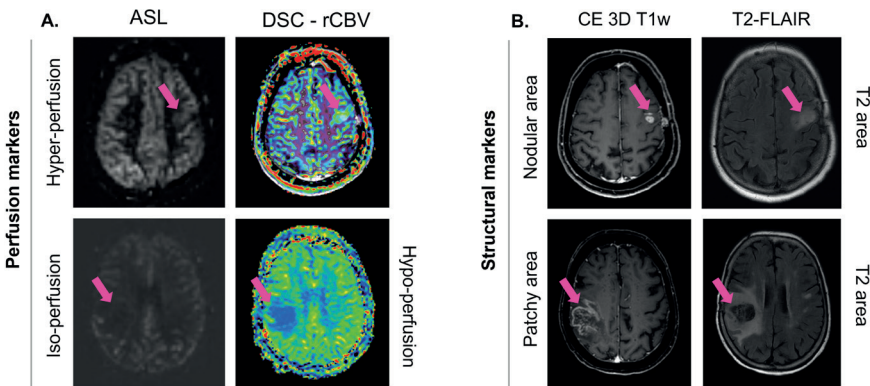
Examples of some of the MRI markers scored by a neuroradiologist. A. Perfusion MRI markers retrieved from corresponding images, namely ASL and DSC-rCBV maps. On the upper and lower row examples of patients with increased and no change/decreased perfusion, for ASL and DSC respectively. In B. contrast enhanced (CE) 3DT₁ and T₂-FLAIR MRI scans from which the structural markers were assessed; it shows examples of nodular and patchy contrast enhancing areas, as well as T₂ hyperintense areas. The scans on each row correspond to one patient.
